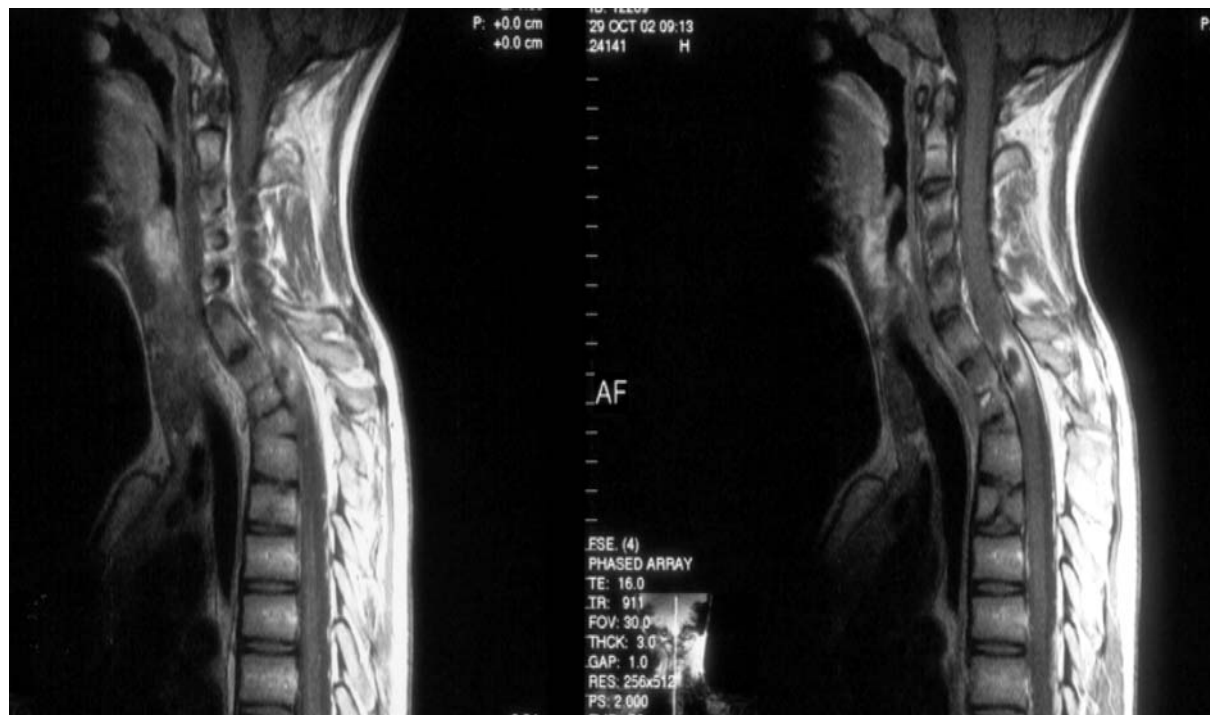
MRI scan (29.10.2002) showing spinal cord edema and intramedullary hemorrhage
